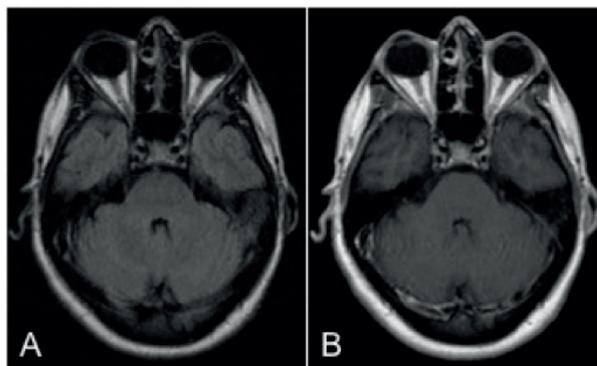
Brain MRI after corticosteroid treatment and remission. (A) Axial FLAIR and (B) gadolinium T1-weighted images obtained through the level of the pons. Complete resolution of infratentorial lesions and no enhancement after gadolinium administration.
